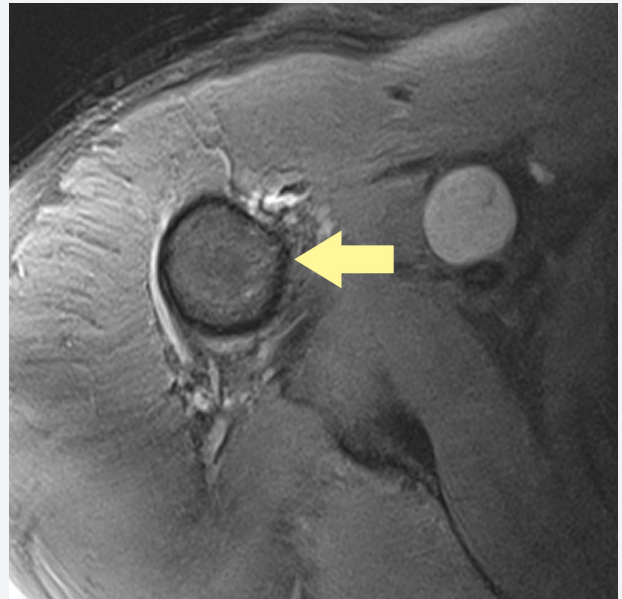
Axial proton density fat suppressed MRI image demonstrating a rounded lesion along the neurovascular bundle (arrow).
